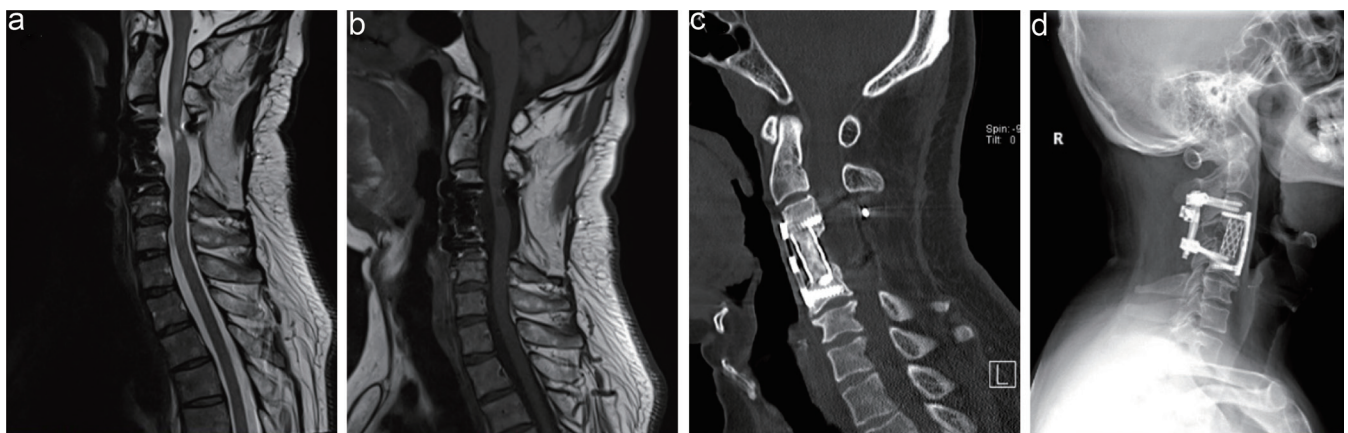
Follow-up MRI, CT, and X-ray 12 months after surgery. The sagittal T2WI (a) and enhanced T1WI (b) MRI revealed that the tumor was removed totally, and there was no recurrent tumor. CT (c) demonstrated good fusion of the vertebral bodies, and X-ray films (d) showed stable fixation of materials without loosening or displacement. CT, computed tomography; MRI, magnetic resonance image; T1WI, T1-weighted image; T2WI, T2-weighted image.
